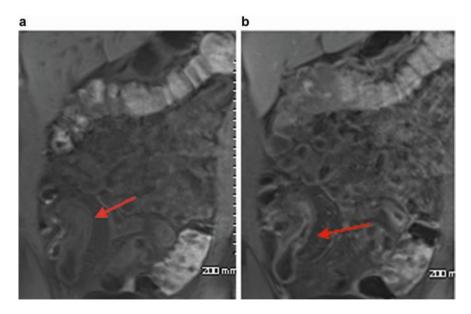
(a) Coronal noncontrast T1-weighted image demonstrates an abnormally thickened segment of terminal ileum (*arrow*). (b) Coronal T1-weighted image obtained at 70 s demonstrates a stratified enhancement pattern of the actively inflamed bowel wall
